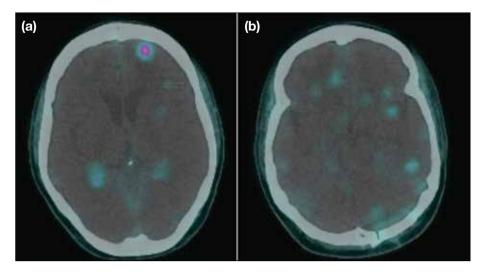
Selected positron emission tomography—computed tomography images using gallium-68-DOTATATE tracer show multiple intra-axial hypermetabolic nodules in the brain and are consistent with known neuroendocrine tumour metastases. No obvious primary malignancy is identified elsewhere.
